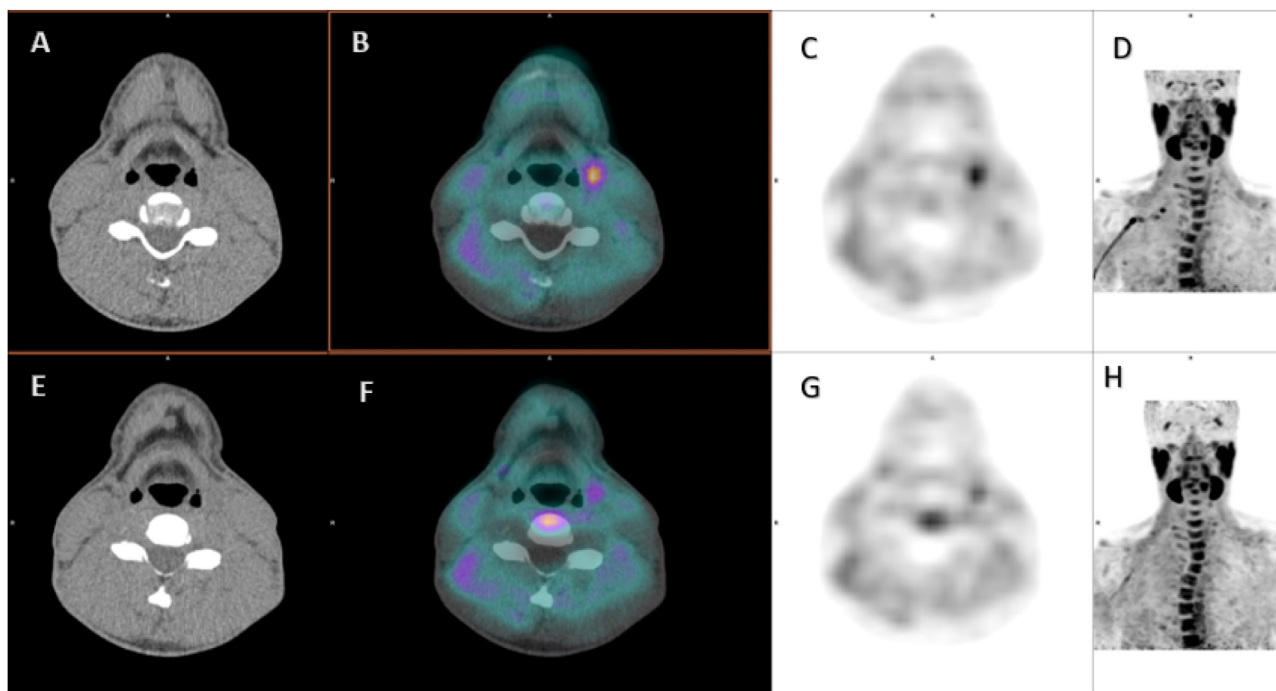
Focal uptake located at left paralaryngeal level that corresponds with pathological ectopic parathyroid gland with better visualization in early images. A, B, C, D: early images. E, F, G, H: delayed images. A, E: axial CT images. B, F: axial PET/CT fusion images. C, G: axial PET images. D, H: MIP images.
